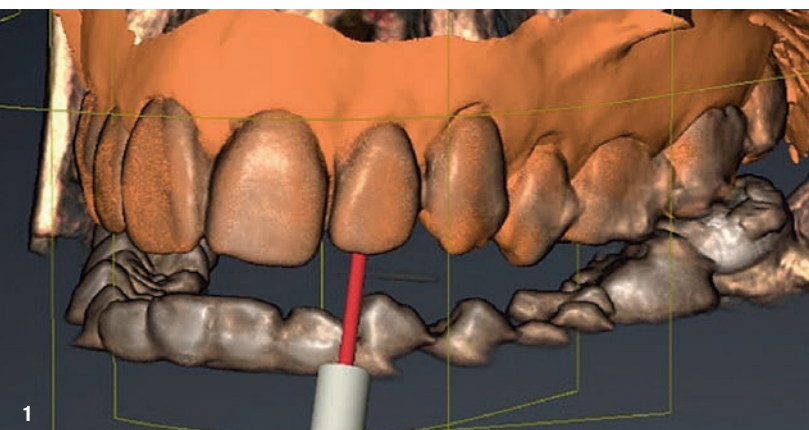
The superimposed digital impression over the CBCT image with a planned pathway.
